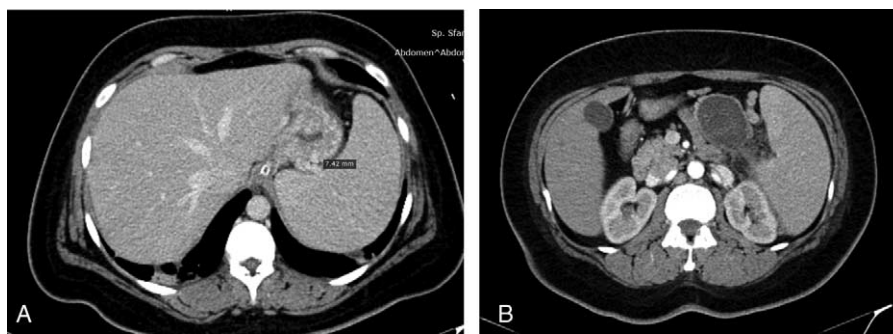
Abdominal CT: January 2017, large gastric varices (A) and gastro-mesenteric shunt (B).
